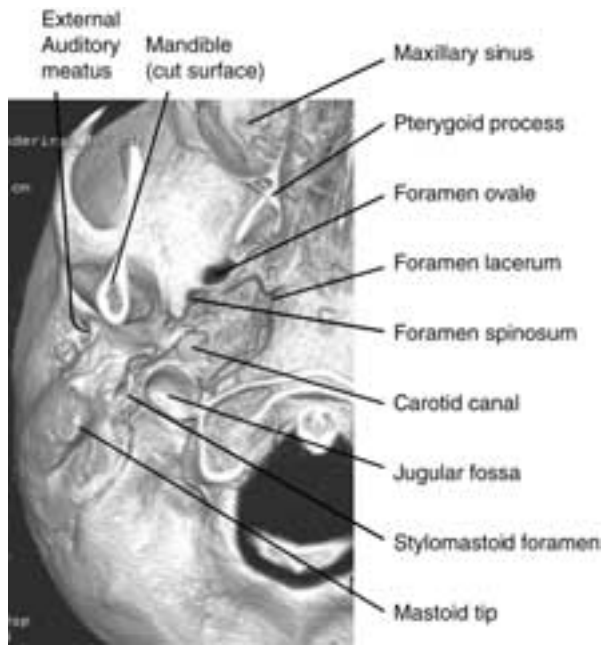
Three-dimensional CT surface reconstruction, inferior view. The oval-shaped jugular fossa is just posterior to the carotid canal. The stylomastoid foramen and the mastoid tip are lateral to the jugular fossa. The foramen spinosum and ovale are just anterior to the petrous apex (not labeled).
